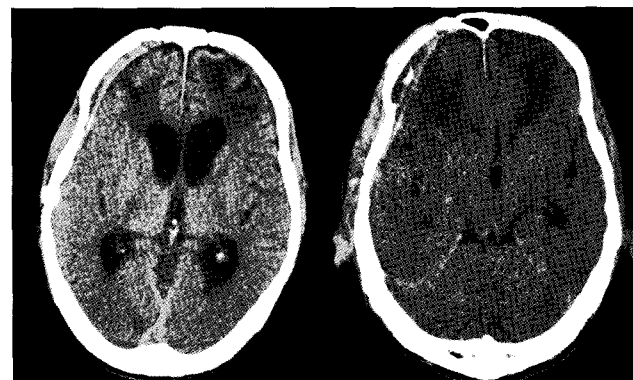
Second postoperative axial CT scans showing the restoration of the shifted midline after cranioplasty.
